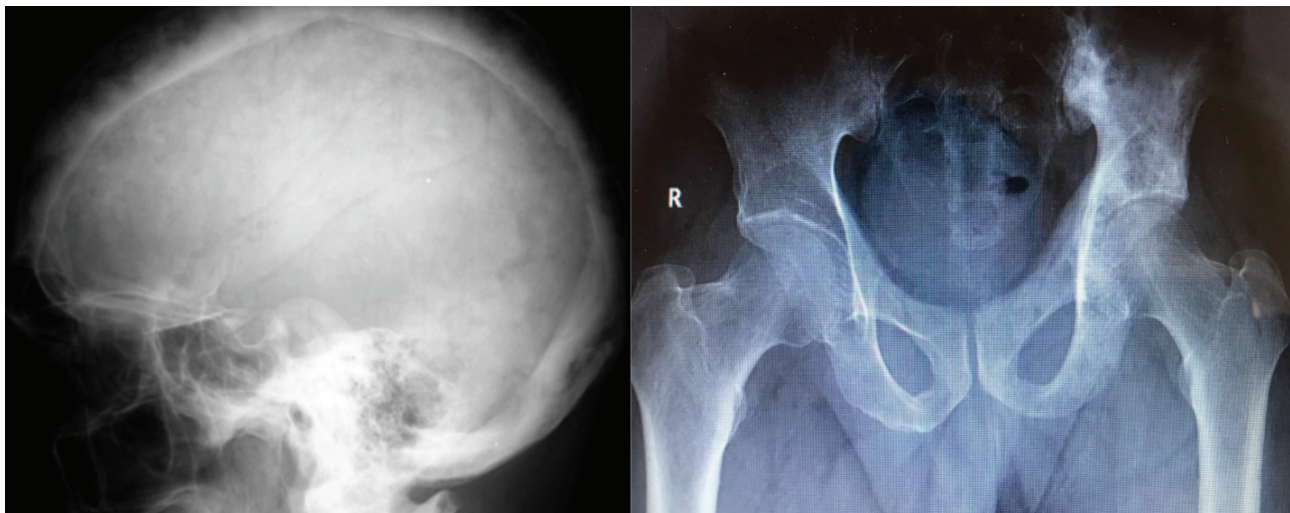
X-rays of cranium and pelvis
